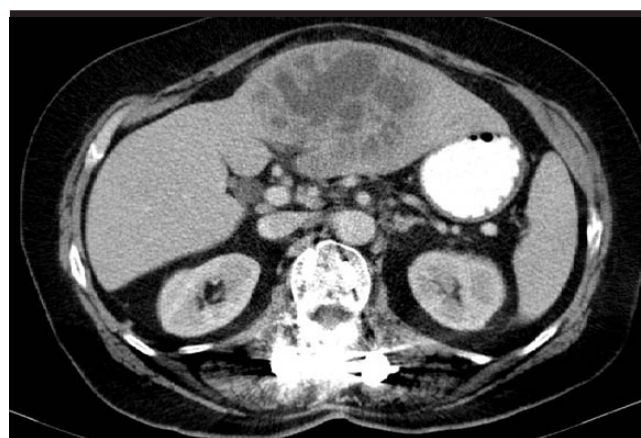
Abdominal CT showing heterogenous multiloculated hypodense mass 206x162 mm.
